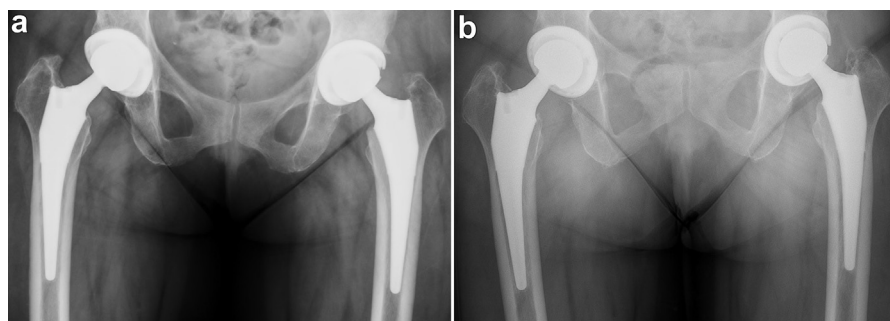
A representative radiograph of a stable femoral component in which there is no significant change in alignment on an AP pelvis radiograph at 1 month postoperative (a) compared to a radiograph at 10 years of follow-up (b).
